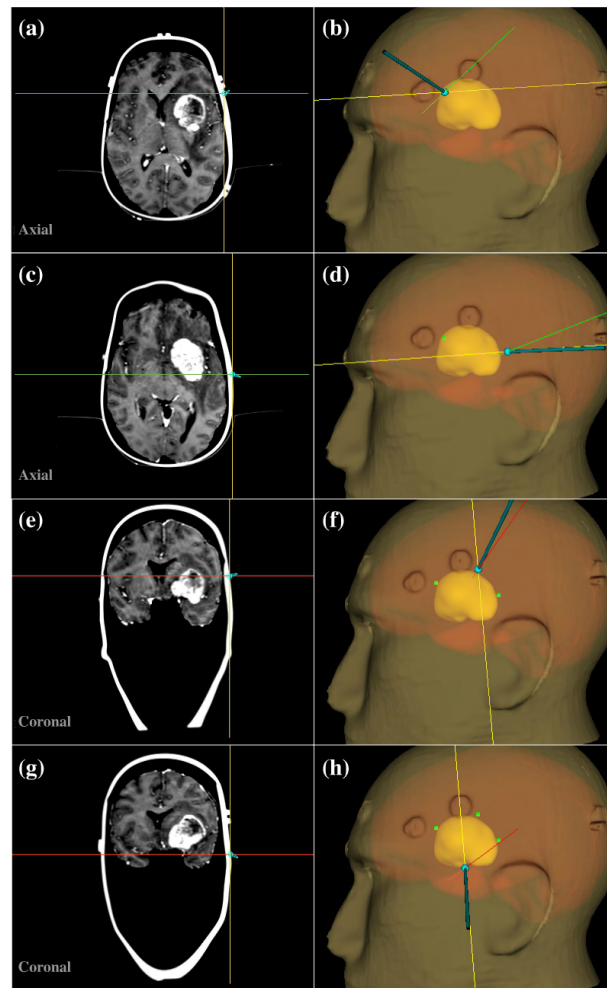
Visualization of determine boundary landmarks for tumors: (a), (b) the anterior boundary; (c), (d) the posterior boundary of the tumor; (e), (f) the superior boundary; and (g), (h) the inferior boundary. In every pair of images, the crosshairs on the MRI correspond to the stylus position on the virtual head.
